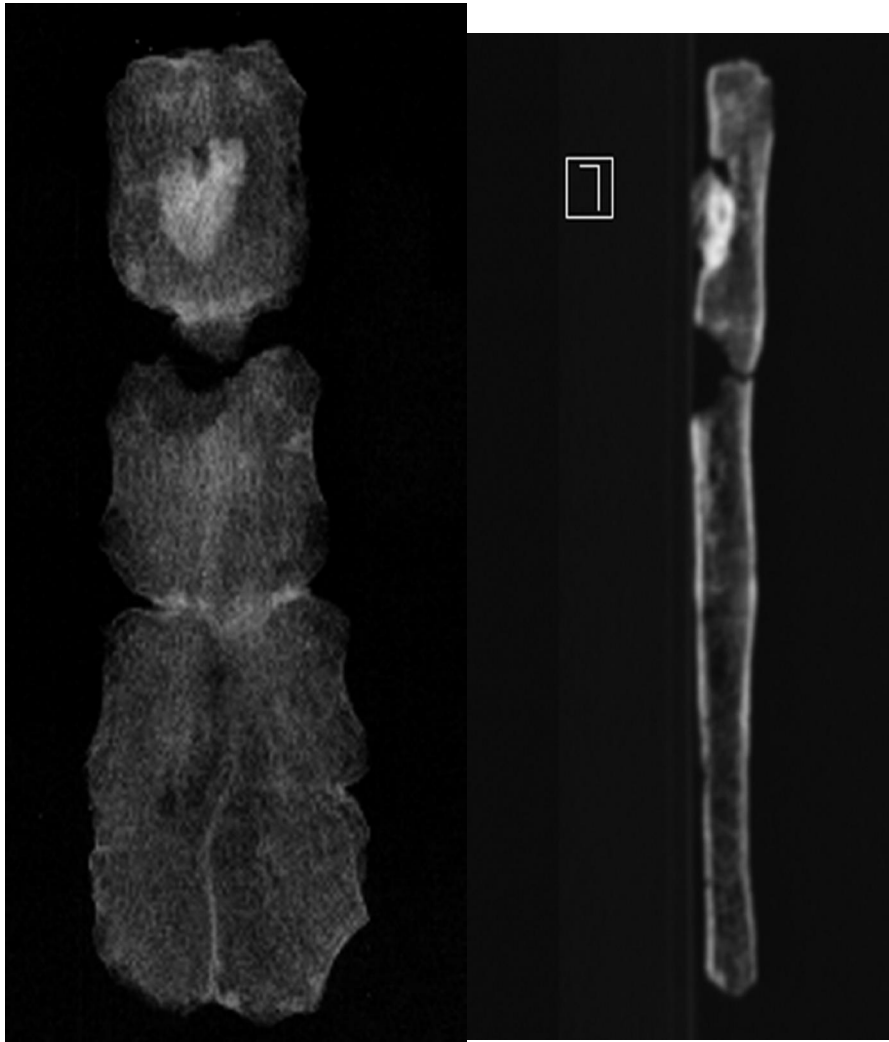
ACD 140. Sternum, Xray, front and profile.
